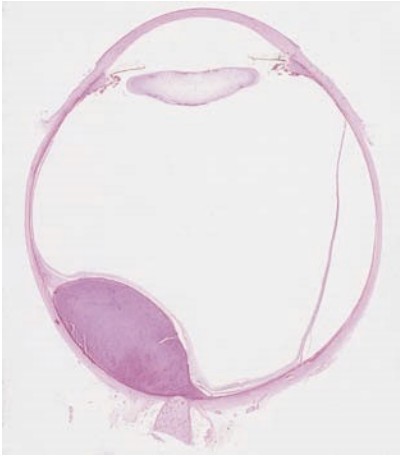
a A prominent yellowish-brown choroidal tumor (thick arrowheads) accompanied by serous retinal detachment (arrows). Compare the ultrasound findings shown in Fig. 126.
